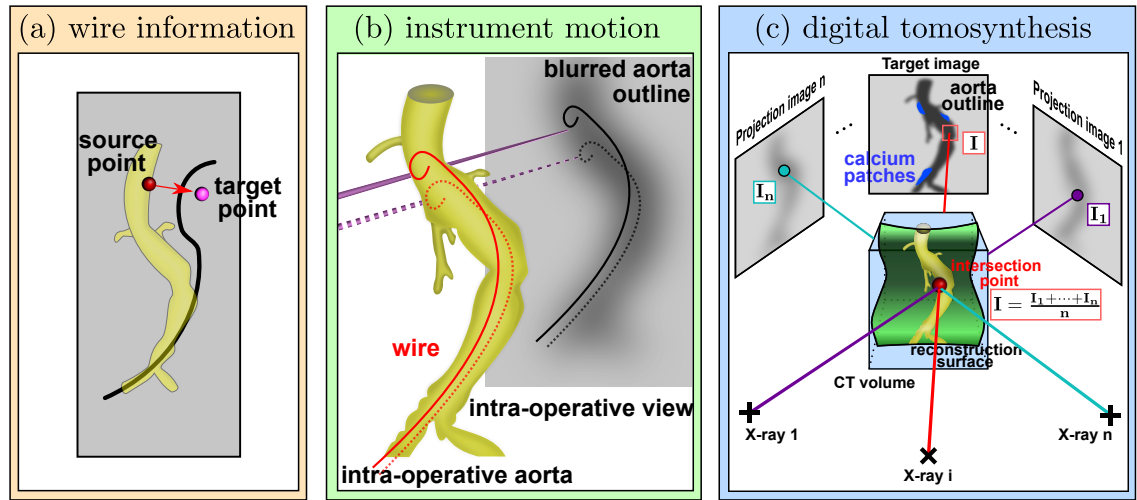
(a) wire information: points can be selected on the aorta surface and the X-ray image to force the surface to encompass intra-operative wires (left picture). (b) instrument motion: the position of the wires can be viewed within a video sequence. Using all the 2D positions, a rough outline of the aorta can be drawn on the fluoroscopy plane. (c) digital tomosynthesis: a ‘sweep’ of the X-ray system arm around the patient provides the surgeons with a series of low soft-tissue contrast X-ray images acquired at different angles. All these X-ray images can be back-projected on a user-defined reconstruction surface tailored to the geometry of the aorta. For each point of the reconstruction surface, an intensity  $I$  is computed as the average of each back-projection ray intensities ( $I_1$  to  $I_n$ ). This intensity  $I$  is projected on a target image. The resulting target image shows a ‘de-cluttered’ X-ray image with information (soft-tissue and calcium deposits) on the structures of the aorta delimited by the reconstruction-surface.
